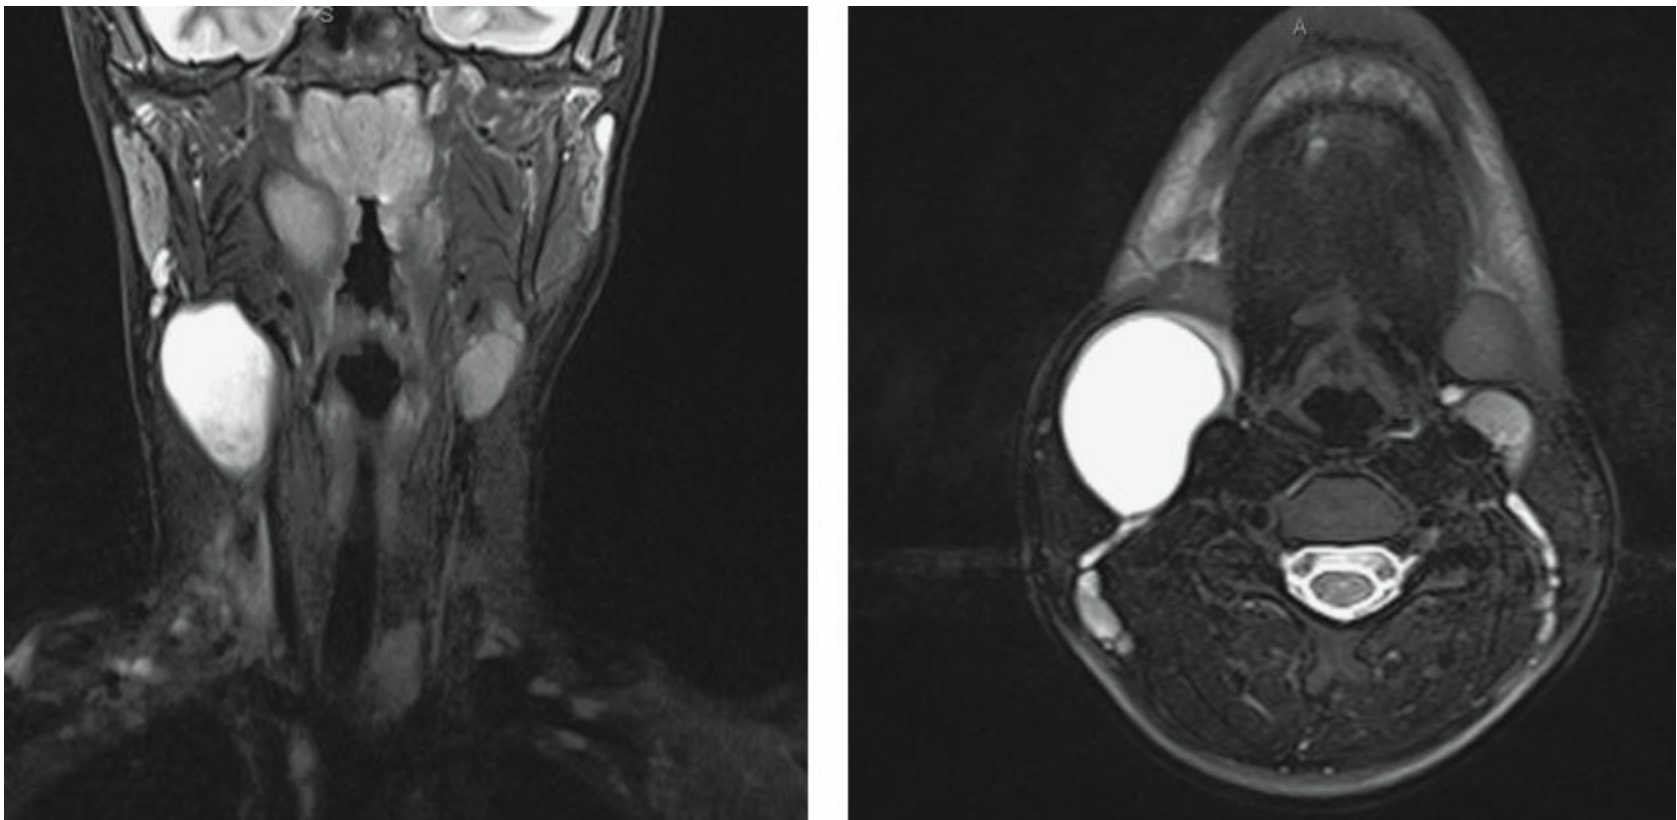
CT or MRI of second branchial cleft cysts.
